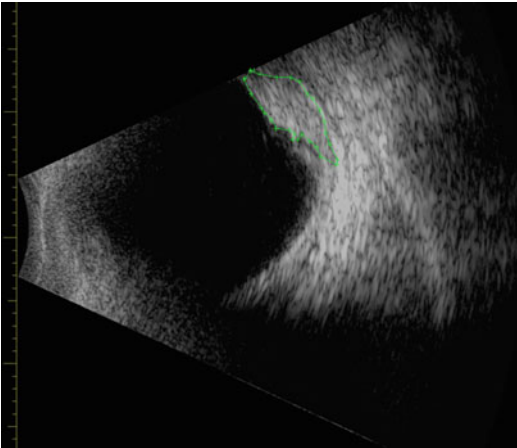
Ultrasound image of a tumor in the eye (melanoma). Frequency 7.5 MHz (corresponding to a wavelength of 0.2 mm)
